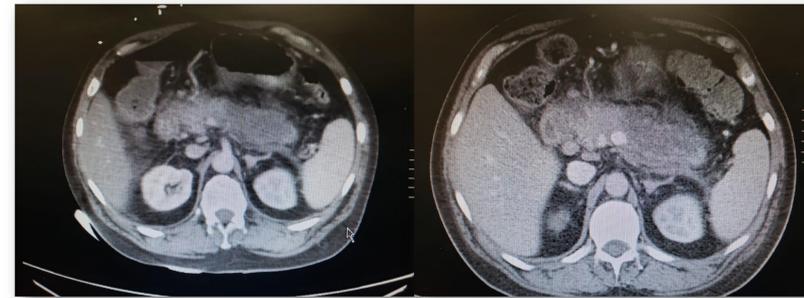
CT scan on day 1 showing pancreatic inflammation and edema of body and tail.
